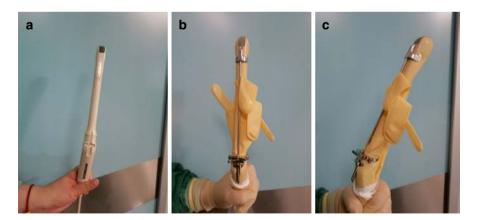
Transvaginal ultrasound probe (transducer) prepared for egg retrieval. (a) The transvaginal ultrasound probe; (b and c) Mounted puncture holder, shown in front and side views, respectively
